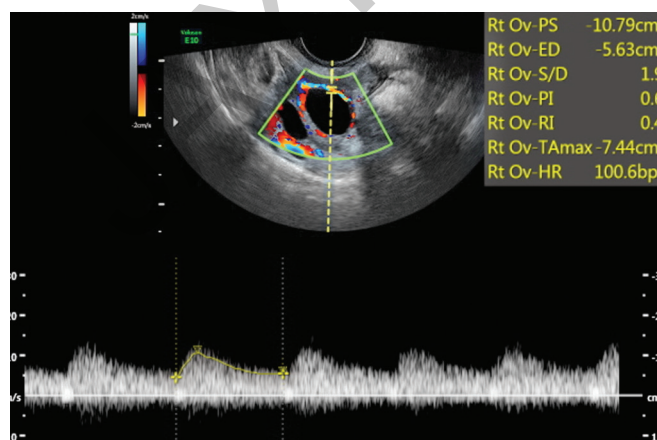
Pulse Doppler image of the low resistance perifollicular flow.
